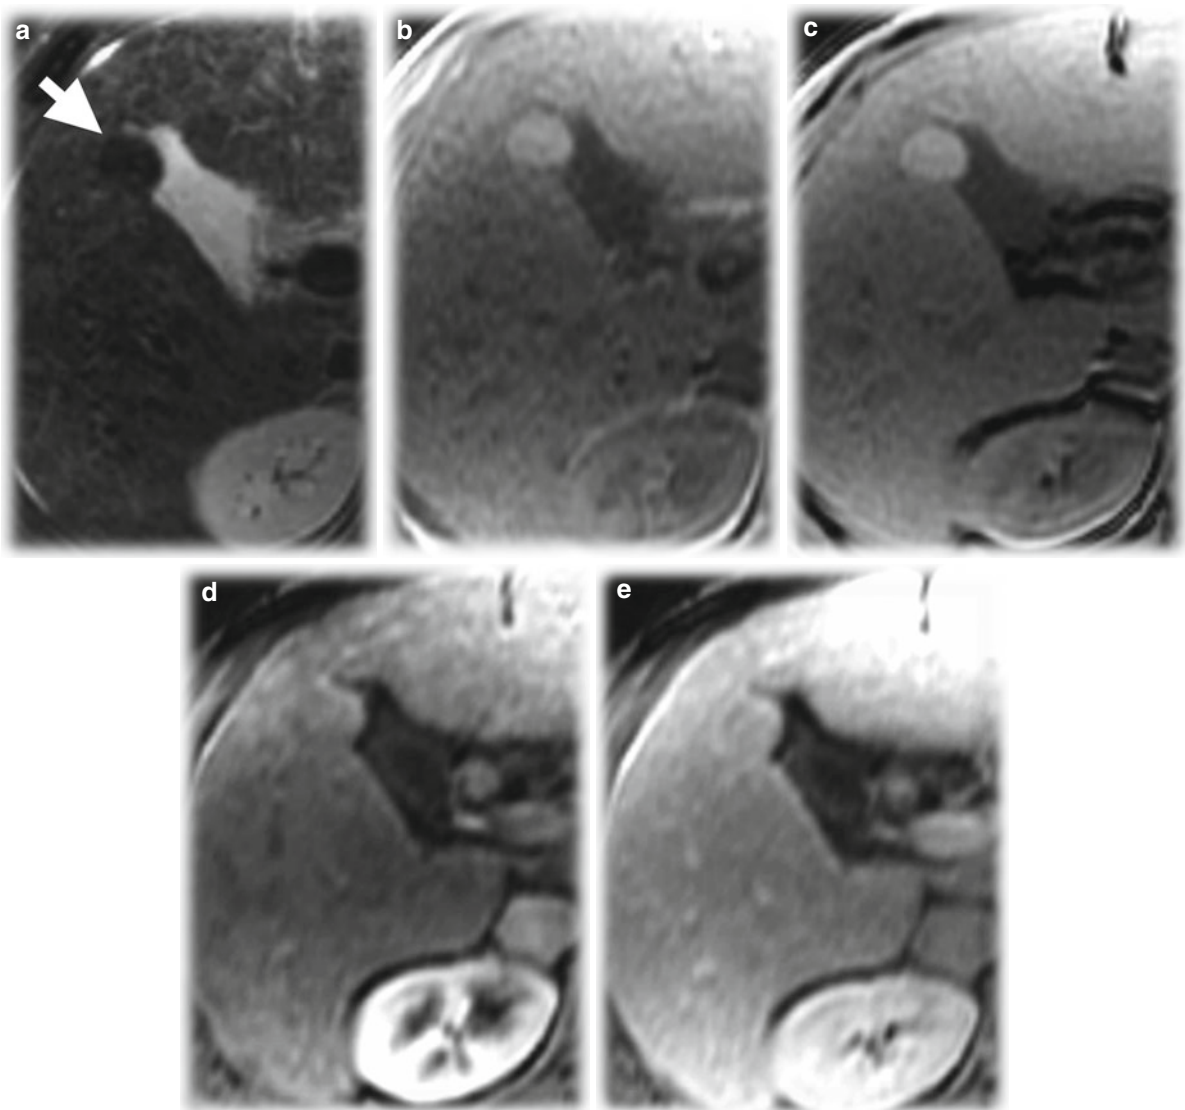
MR scans show a dysplastic nodule in a cirrhotic liver. (a) Transverse T2-weighted turbo spin-echo MR image shows a hypointense mass (*arrow*) in the inferior right lobe of the liver. The mass is hyperintense on the T1-weighted breath-hold
